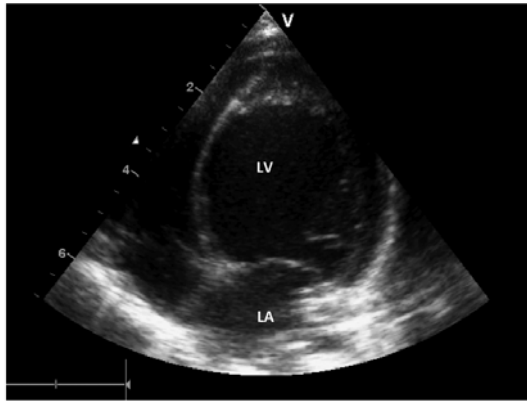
Cross sectional (two dimensional) echocardiogram reveals a significant dilatation of the left atrium and left ventricle at the age of 5 weeks. The estimated left ventricle ejection fraction at that time was about 20%.
